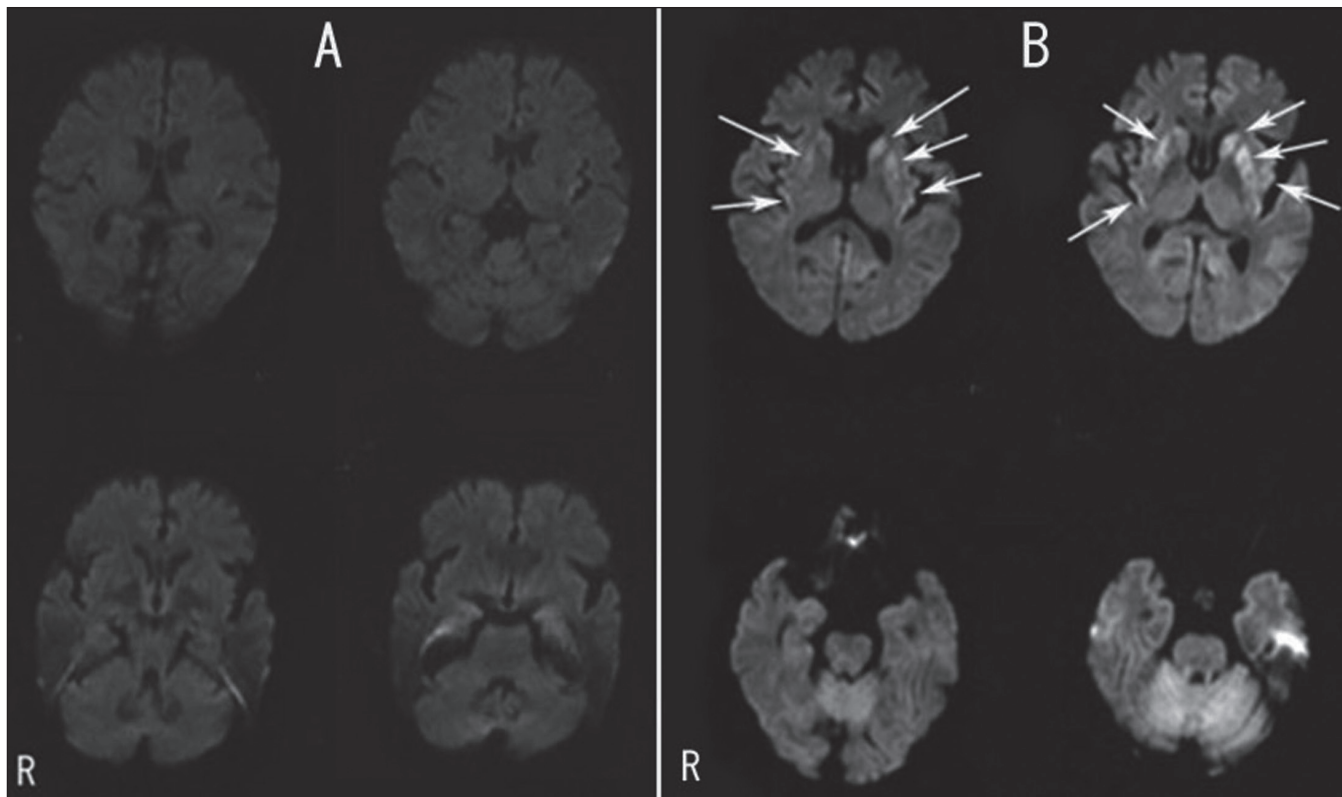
a) MRI at 2 months after onset (September 2005). Axial DWI shows no abnormalities. b) MRI at 3 months after onset (October 2005). Axial DWI shows bilateral abnormalities in the cerebral cortex, putamen, and caudate head.
